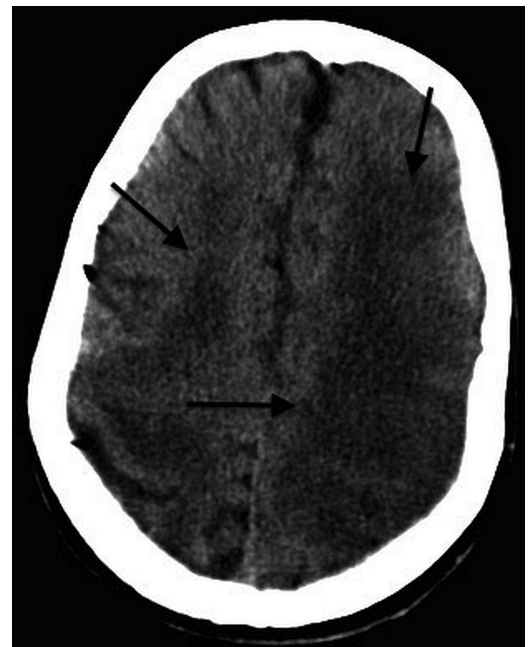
CT of the head showing severe bilateral oedema secondary to acute stroke likely of embolic origin.
